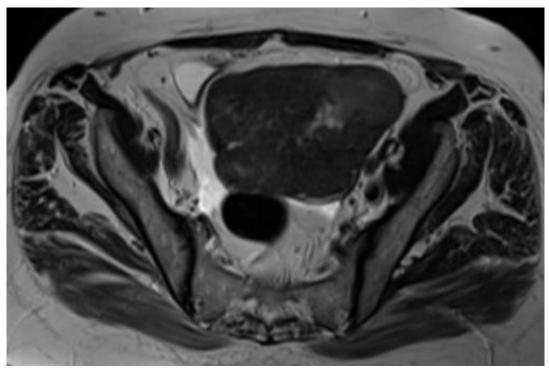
Coronal MRI image of a 58-year-old female patient. Solid white arrows show a hypointense solid mass with cystic components in the upper part of the bladder.
